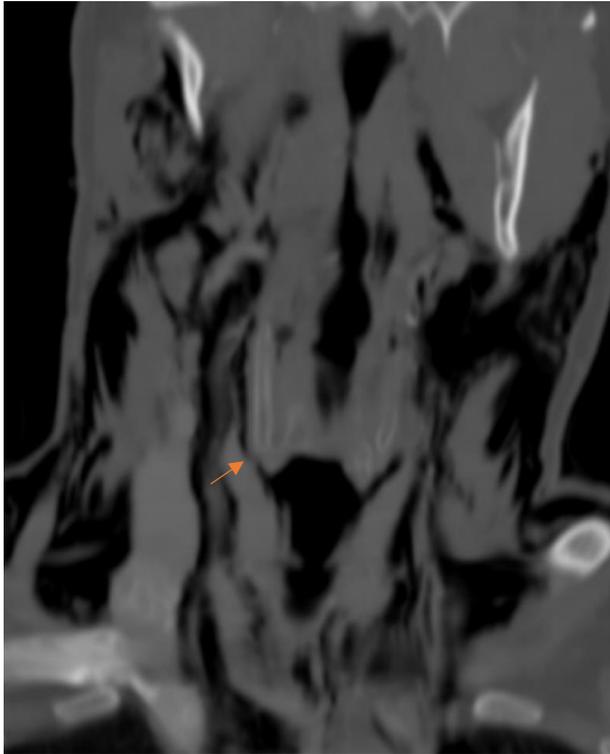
Thin cut coronal computed tomography of a 55-year-old hanging victim through the level of the cricothyroid notch demonstrating complete separation of the more distal trachea from the cricoid cartilage. The arrow demonstrates the inferior border of the lateral cricoid cartilage.
